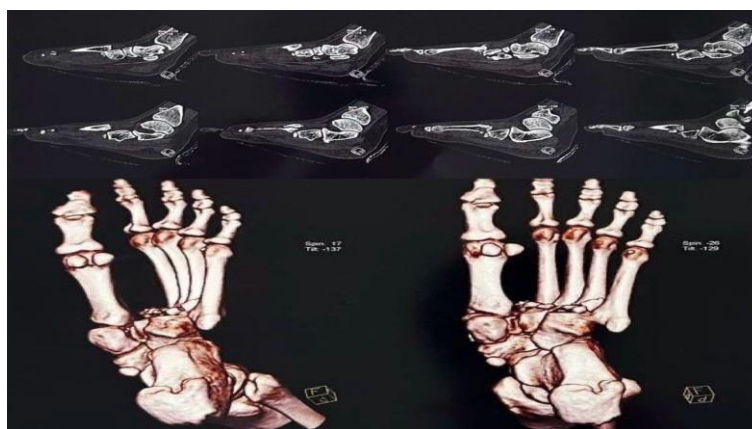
Case 1: CT scan Showing the Extent of the Fracture and 3D Reconstructions.
